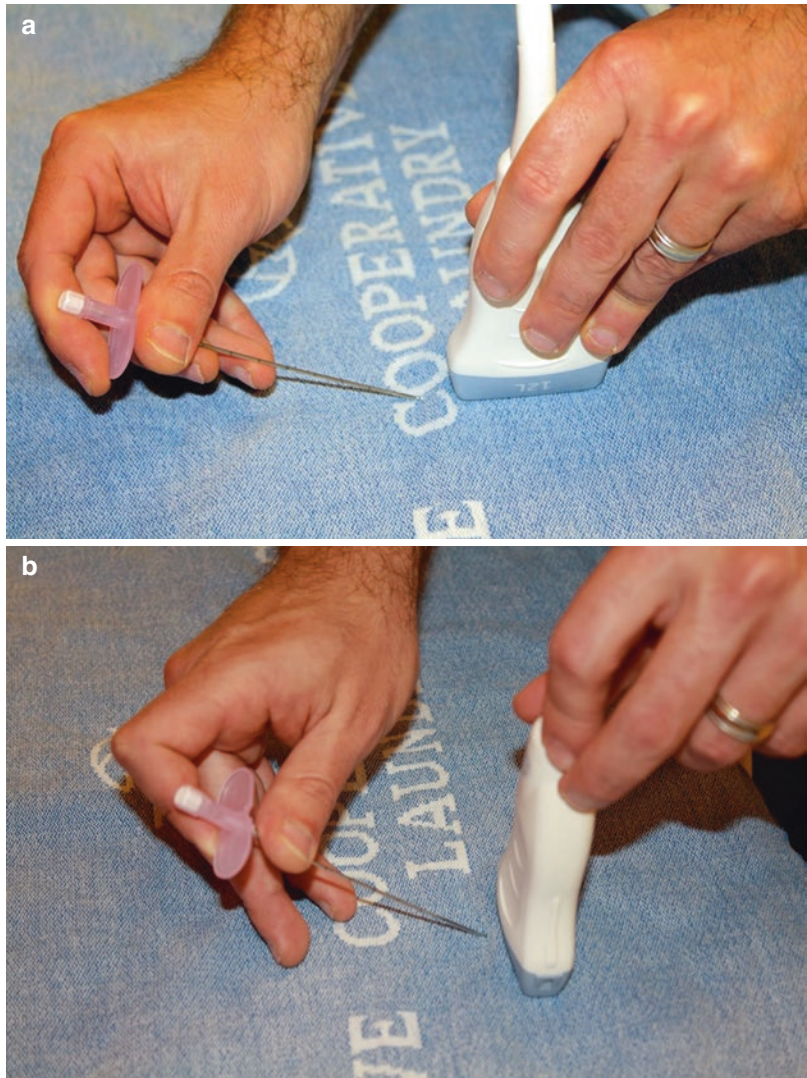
The basic principles of ultrasound probe manipulation are pressure, rotation, alignment, and tilting
